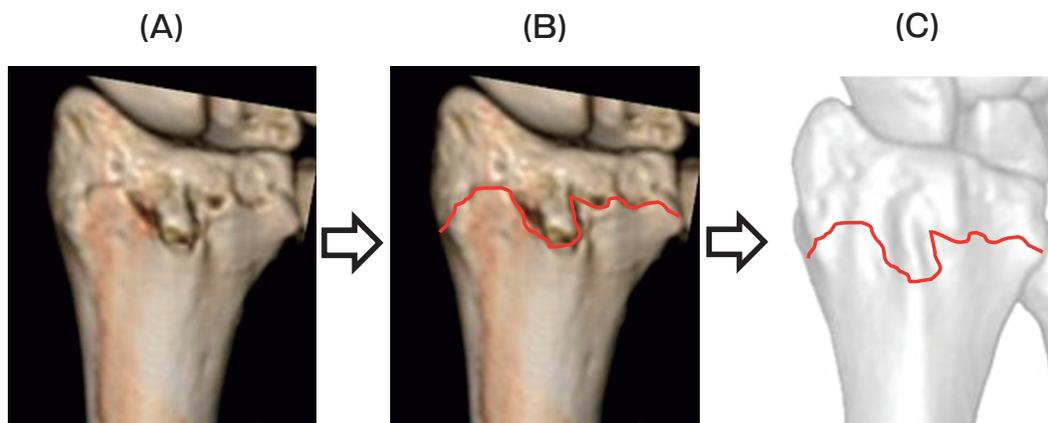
Images showing two-dimensional fracture mapping. (A) Image of computed tomography. (B) Image with fracture lines drawn as red lines. (C) The fracture lines were drawn onto a standard two-dimensional template of an intact distal radius by matching landmarks.
